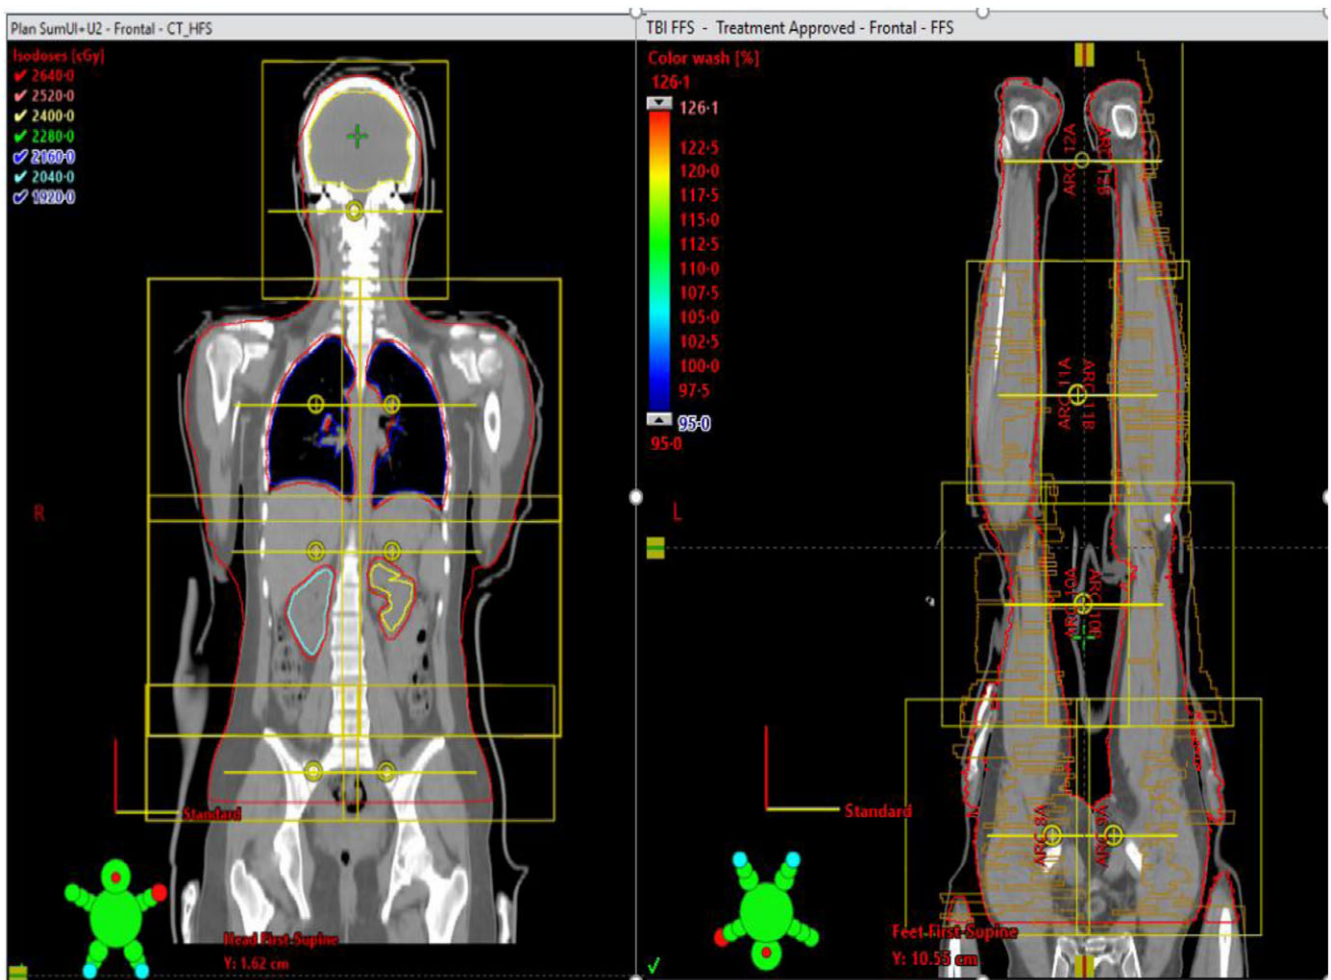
Field (yellow rectangles) and isocentre (yellow dots) for headfirst CT with one isocentre in head and neck, and with two coplanar isocentres in chest/abdomen and pelvis.
